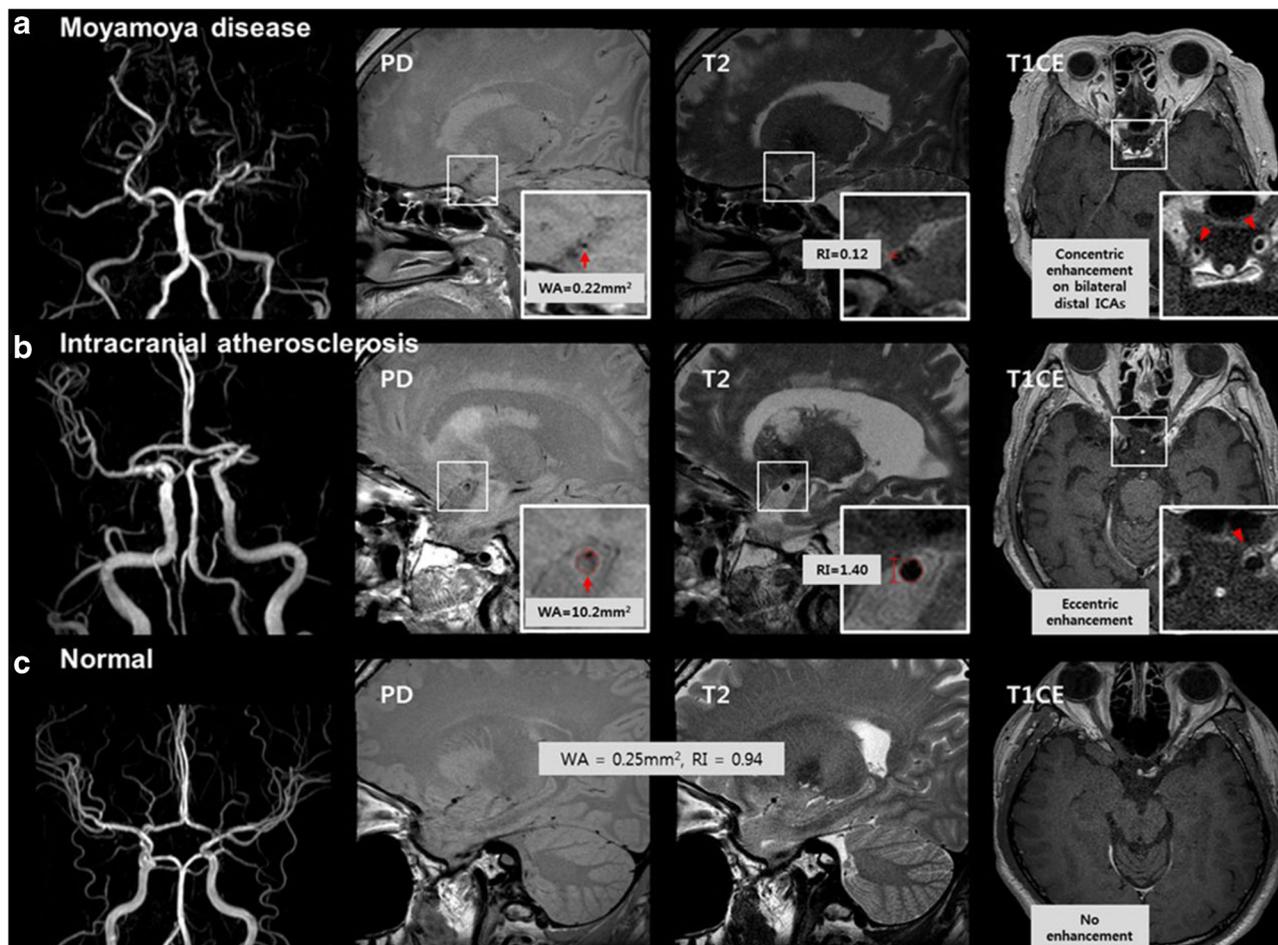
Moyamoya disease. Reprinted with permission from Ryoo et al., American Heart Association [77]. “Cases of moyamoya disease (MMD), intracranial atherosclerotic disease (ICAD), and a normal control showing different high-resolution MRI findings. a MMD showing shrinking middle cerebral artery (MCA; arrows) and concentric enhancement on bilateral distal internal carotid arteries (ICAs; arrowheads). b Thick MCA with positive remodeling (arrows) in ICAD. Enhancement of the left distal ICA is eccentric (arrowhead). c Normal control has MCA without shrinkage or plaque and no enhancement on distal ICAs.” PD, proton density; T1CE, T1 contrast-enhanced; WA, wall area; RI, remodeling index.
